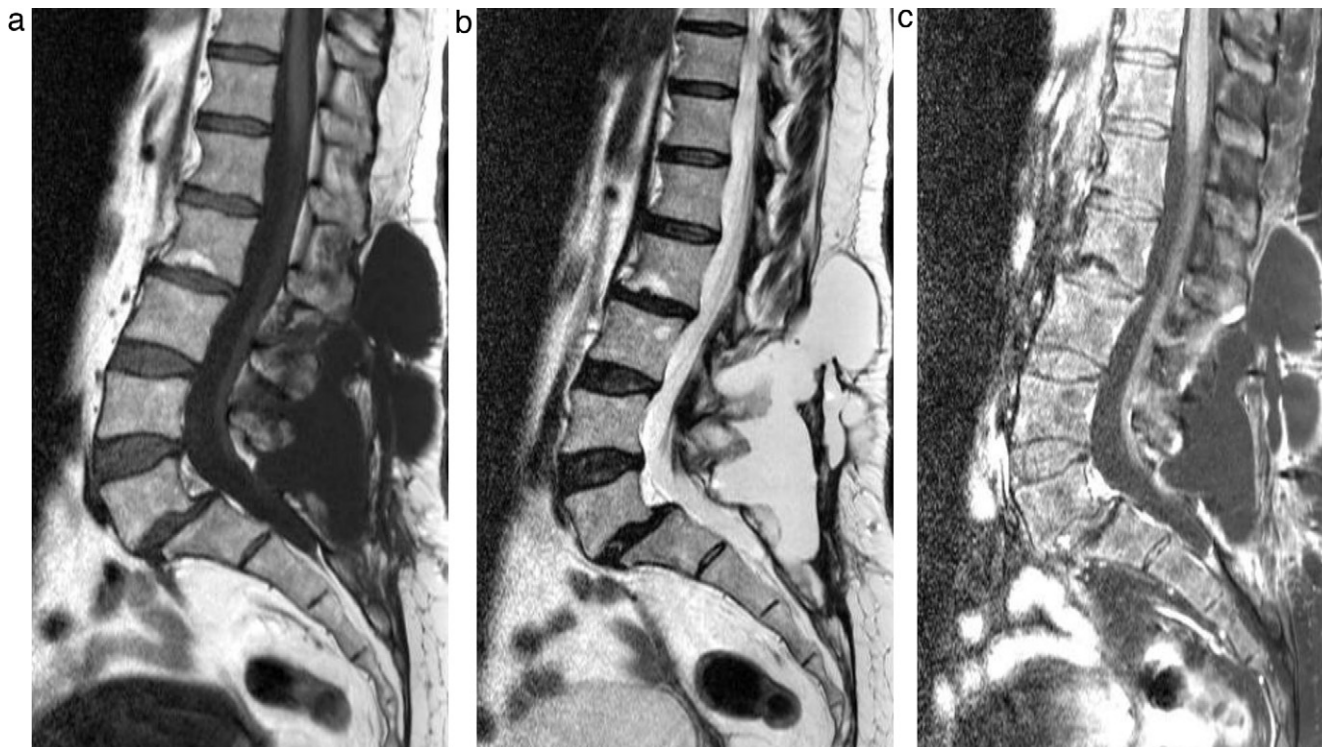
Sagittal magnetic resonance images. Sequence T1 (A), T2 (B), Spir with gadolinium enhancement (C). The cerebrospinal fluid leak of this pseudomeningocele was completely contained. There was no leakage from the incision site.
